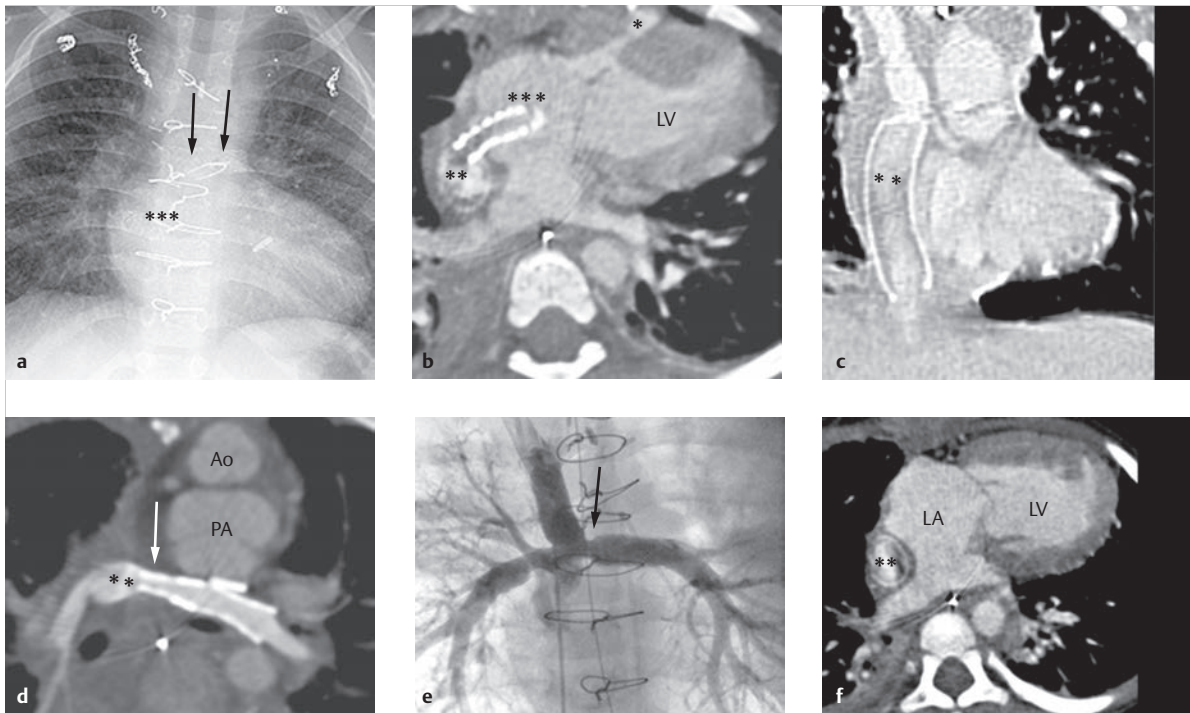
Functionally univentricular heart. Four-year-old male patient with tricuspid atresia and functionally univentricular heart with left systemic ventricle. Condition after palliative treatment by means of extracardiac TCPC (b, c, d, f, double asterisk). The reconstructions from a contrast-enhanced CT depict parietal thrombi in the conduit of the TCPC (b, c, f, double asterisk), as well as flow artifacts.
